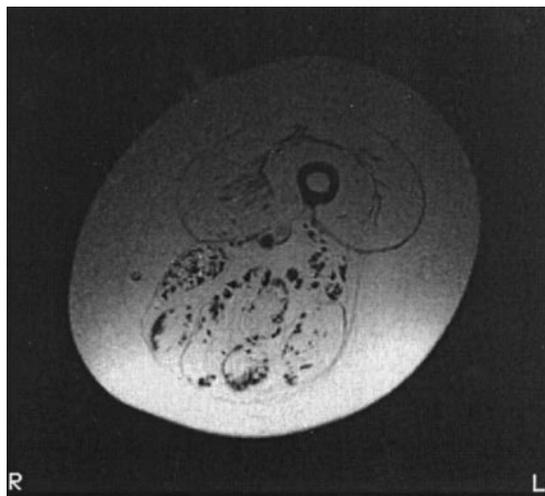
MRI of the patient's thigh showing profound muscle atrophy and diffuse fat infiltration.
